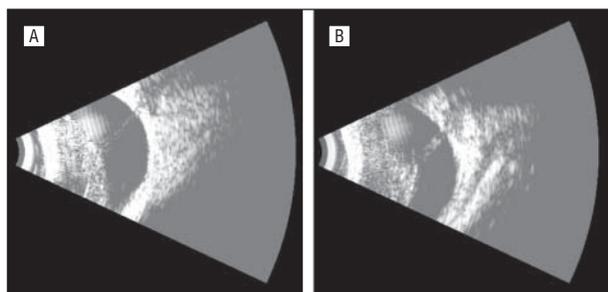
Ultrasonographic images (12 MHz) demonstrating tight funnel-shaped retinal detachment in the right (A) and left (B) eyes.
